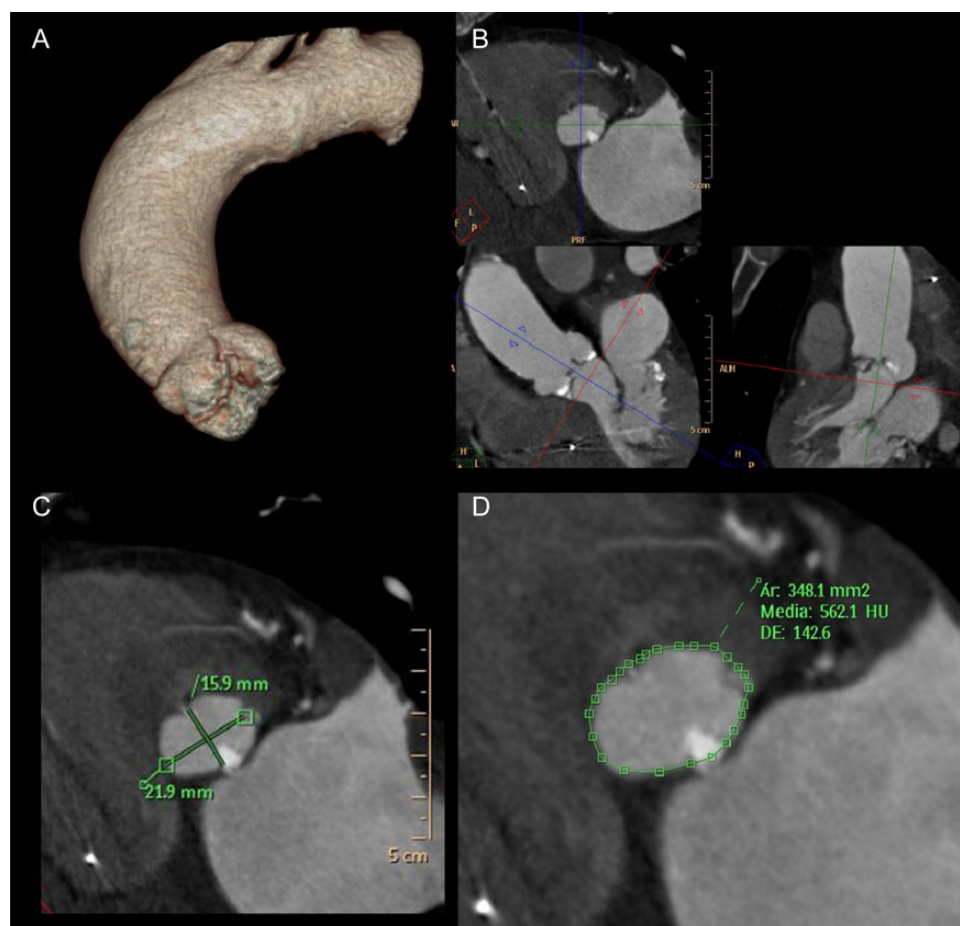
Multi-slice detector computed tomography reconstruction of the aortic root and ascending aorta (A); 3D orientation for aortic annulus measurement (B); aortic annulus diameters (C) and area and planimetry (D) measurement.
